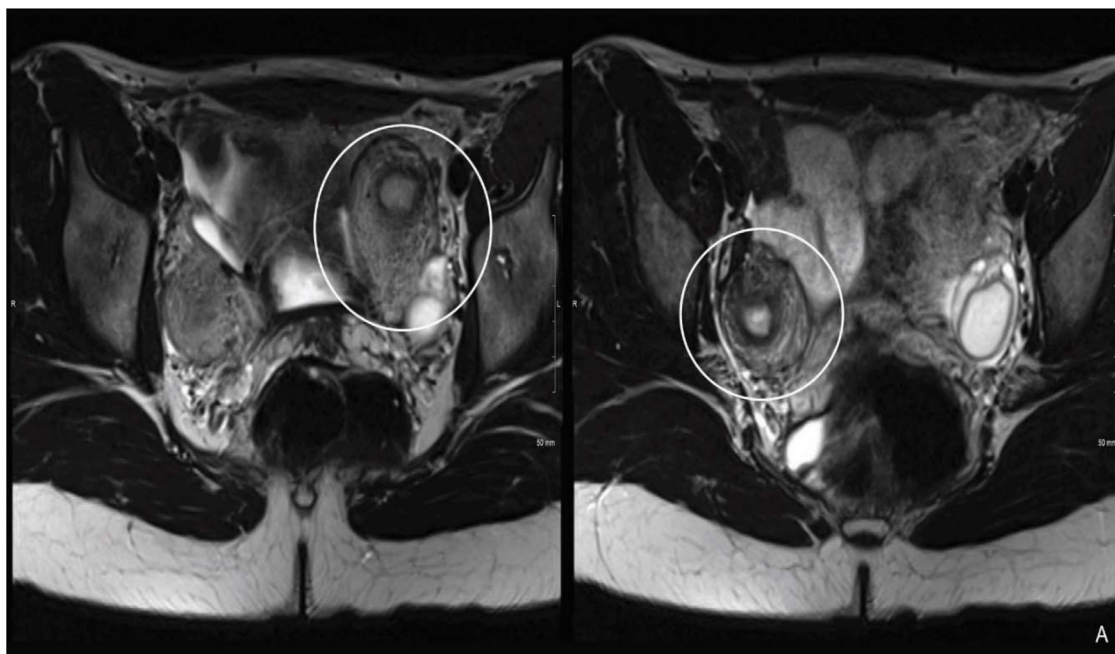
Magnetic resonance imaging of the pelvis confirming the ultrasound findings with additional details. Non-fat sat axial T2 weighted images (A, B). (A) show 2 widely separated uterine horns (White circles) with well appreciated normal zonal anatomy and normally appearing non-communicating endometrial cavities of high signal intensity. (B) At lower level there is a dark signal intensity band/tissue at expected location of the lower uterine segment and cervix (Yellow arrow) and normal lower one-third of the vagina (White arrow). (C) Non-fat sat sagittal T2 weighted image shows the poor anatomical differentiation and development of the cervix/upper vagina (Yellow arrow) and the present lower vagina (White arrow). A thin dark T2 signal intensity fibrous band between the 2 horns converging into midline was seen (not shown here). (D) Coronal fat sat T2 weighted image shows bilateral normal ovaries with multiple physiologic follicles. (E) Non-fat sat coronal T2 HASTE shows normal kidneys are present in its anatomical position.
